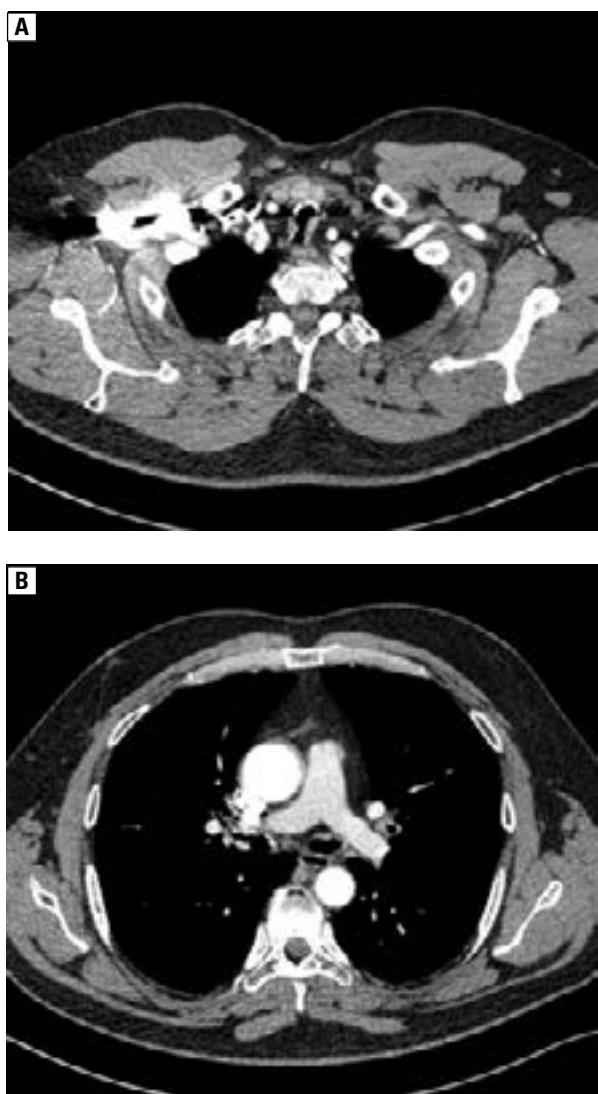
A CT images reveal narrowing of trachea (A) and main bronchi (B) with multiple protruding nodules and calcifications in their walls
